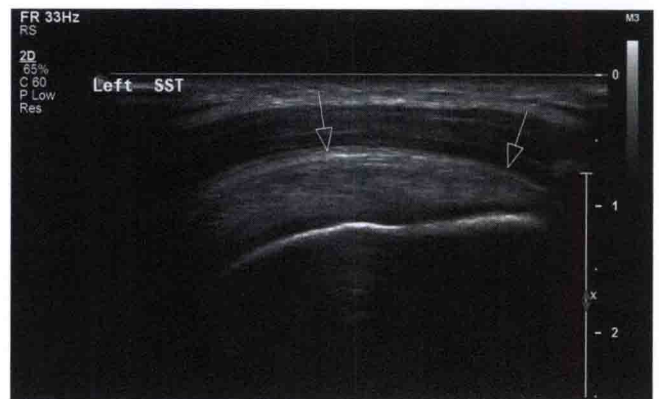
Normal supraspinatus tendon on longitudinal ultrasound view. (A) The probe is positioned perpendicular to the tendon. (B)
